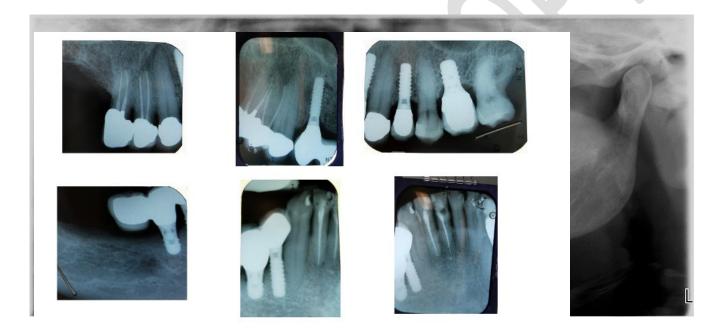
Orthopantomogram and periapical survey, showing the extensive dental work previously done.
